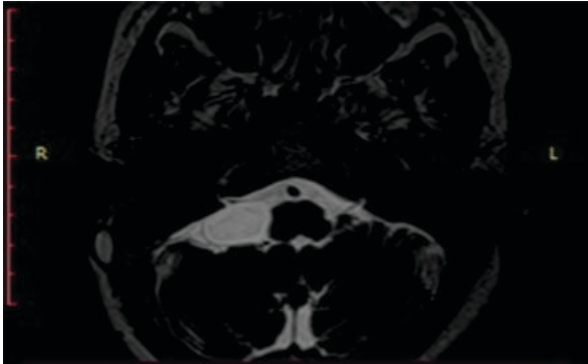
(b) Axial T2-weighted MRI shows the cyst displacing the vascular structures of the CPA.
